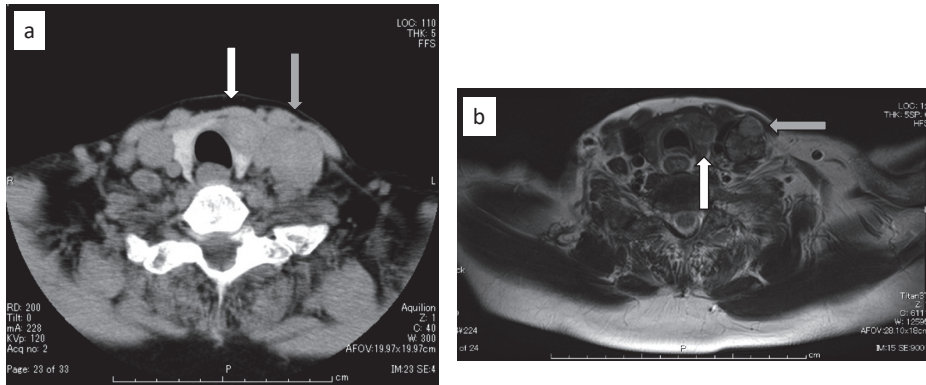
CT (a) and MRI (b) showing a lt. lobe mass (white arrow) and a lt. cervical lymph node (gray arrow).
